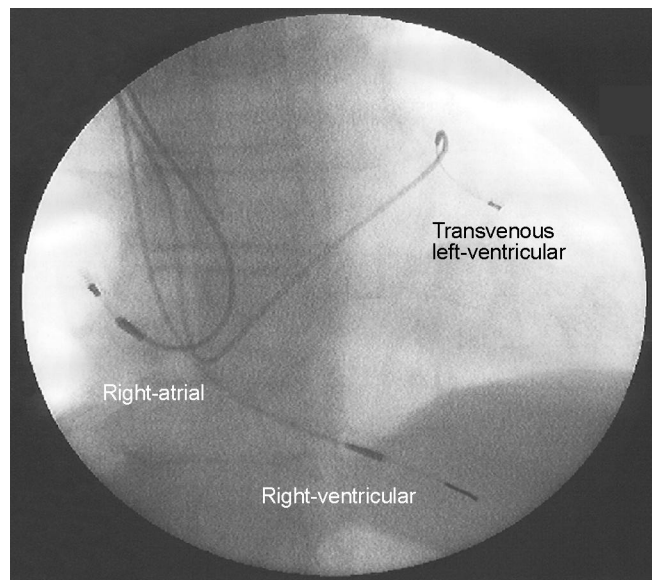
Chest X-ray showing a left atrial lead, a right apical lead and a coronary sinus lead.
